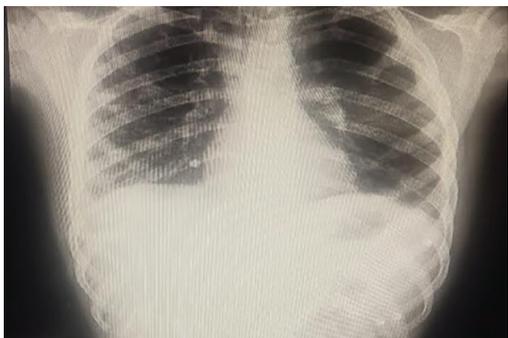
Chest X-ray on day 12
